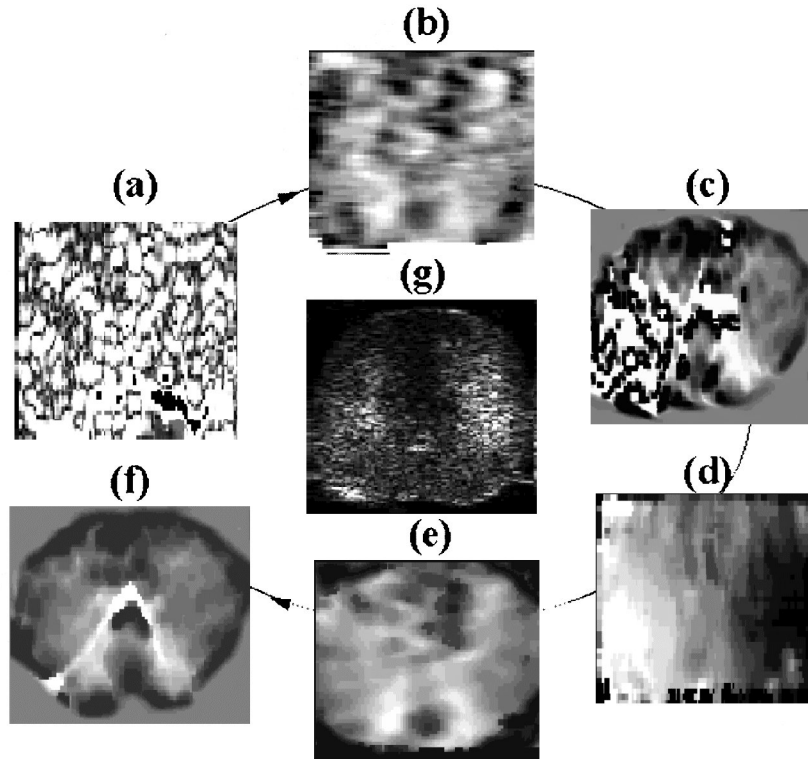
In vitro* anterior–posterior view of a canine prostate at 2 per cent axial compression (elevationally confined): (a) first axial elastogram (no axial or lateral corrections), (b) first lateral elastogram (no axial correction), (c) second axial elastogram (with axial correction, no lateral correction), (d) lateral displacement image (with axial correction), (e) second lateral elastogram (with axial correction), (f) third axial elastogram (with axial and lateral corrections) and (g) sonogram (i.e. envelope of the RF sonographic data)
